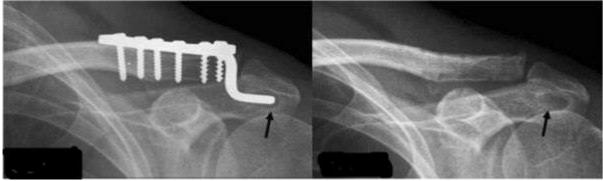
M, 38Y, accident fall on the shoulder, post-operative radiograph with acromial bony erosion.
